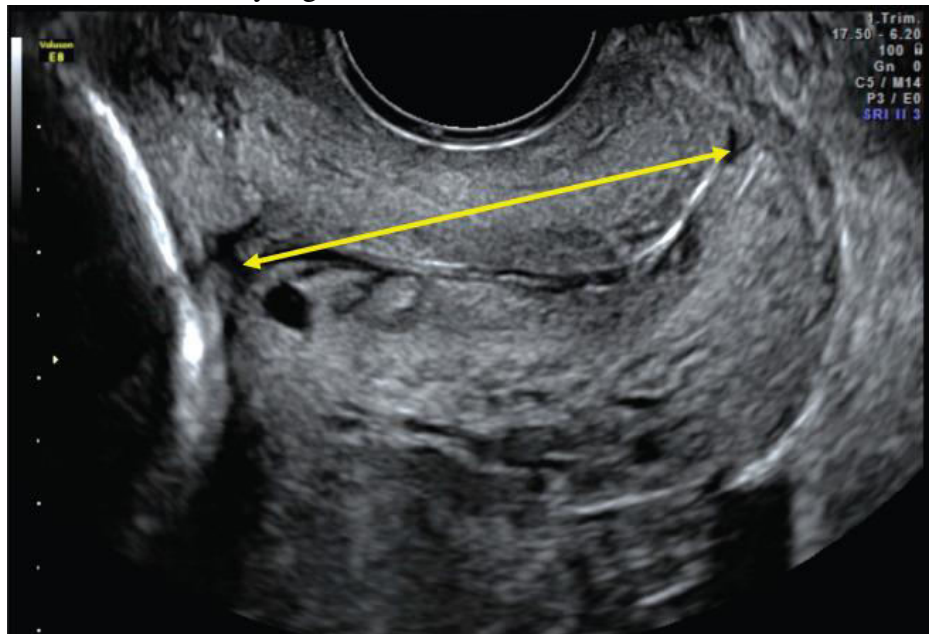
Cervical length using Transvaginal ultrasound
